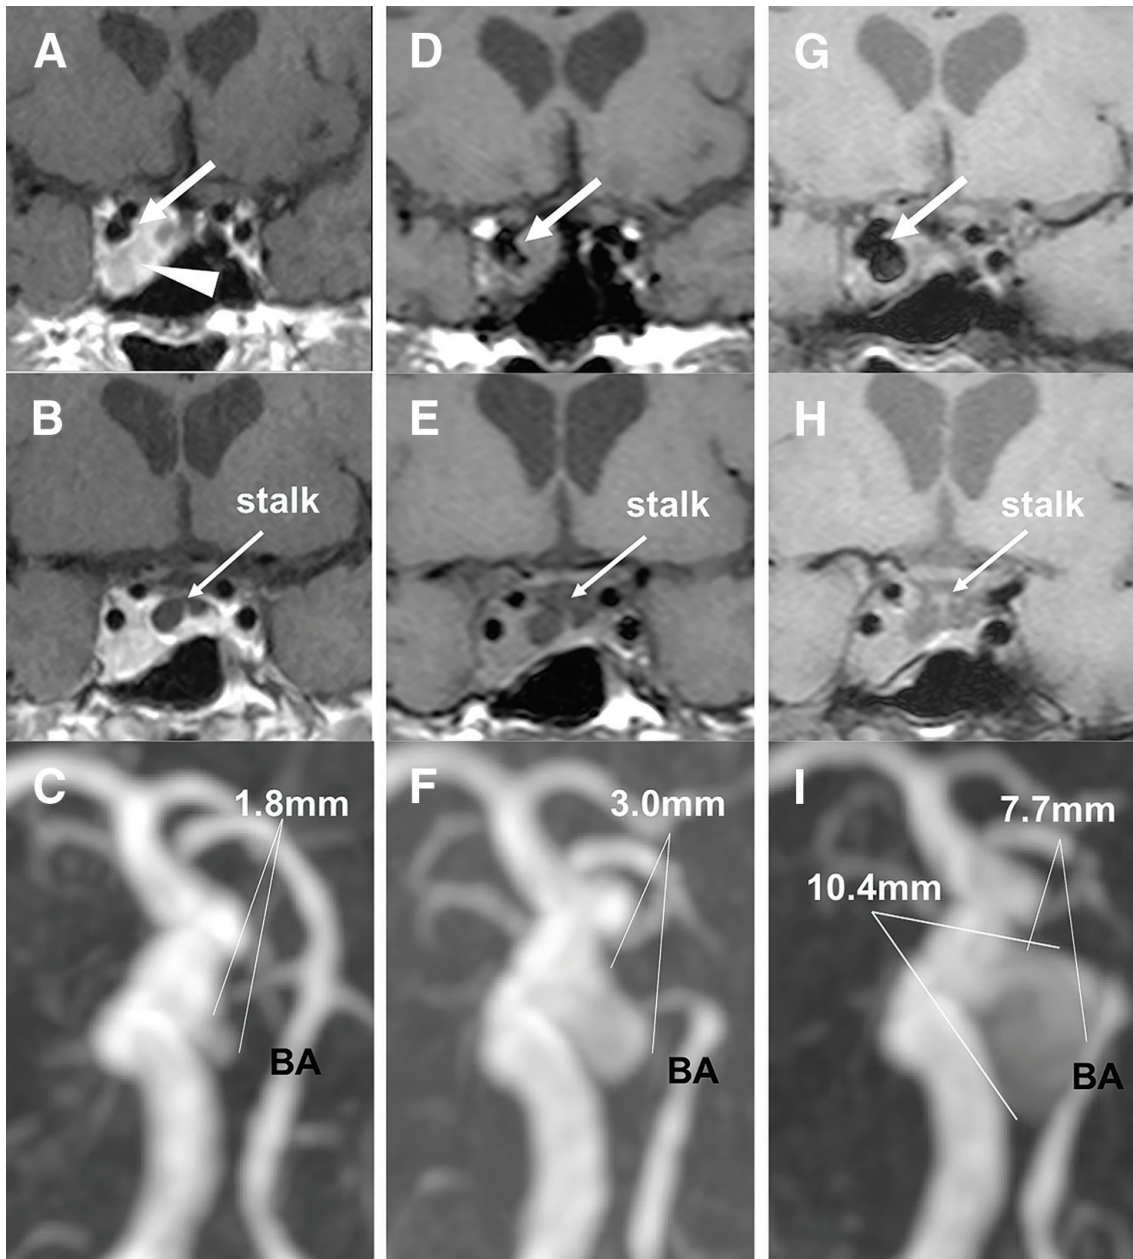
Coronal MRI and MRA findings. Coronal T1-weighted sequence with GE images (A and B) and MRA (C) 30 months after cabergoline treatment of the prolactinoma. T1-weighted sequence with GE (A) reveals that the prolactinoma (arrowhead) extended to the lateral side of the ICA and is contiguous with the aneurysm (arrow). The coronal T1-weighted magnetic resonance images (D and E) and MRA images (F) 56 months after the initial treatment. Coronal fat suppression T1-weighted magnetic resonance images (G and H) and MRA images (I) 81 months after the initial treatment. A new aneurysm emerged in the cavernous portion of the right ICA (arrow) and has grown larger during the treatment of the prolactinoma (C, F, and I). MRI: magnetic resonance imaging, MRA: magnetic resonance angiography, GE: gadolinium enhancement, ICA: internal carotid artery, BA: basilar artery.
